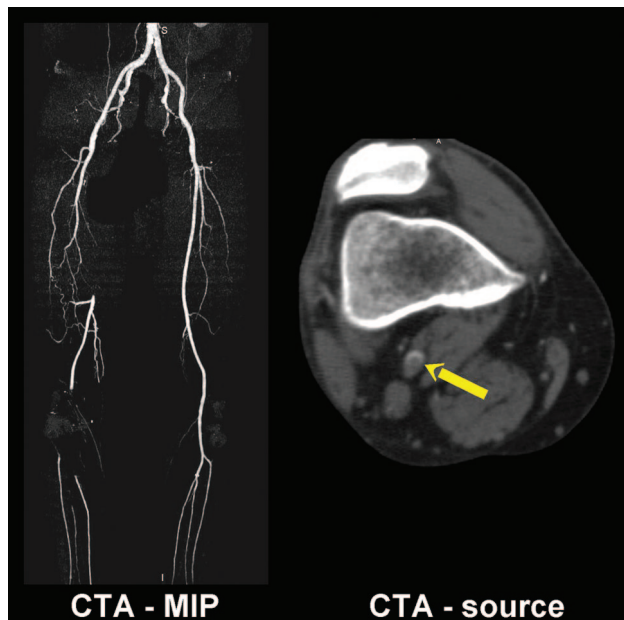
Maximum-intensity projection (MIP) image of a standard runoff CTA performed on a 64-detector-row CT scanner. Note occlusion of superficial femoral artery with reconstitution of a blind segment of popliteal artery and occlusion of the proximal trifurcation arteries. Axial source image from below the knee (right panel). Note the meniscus of contrast (arrow) at the right popliteal artery indicating acute thrombus or embolus.
